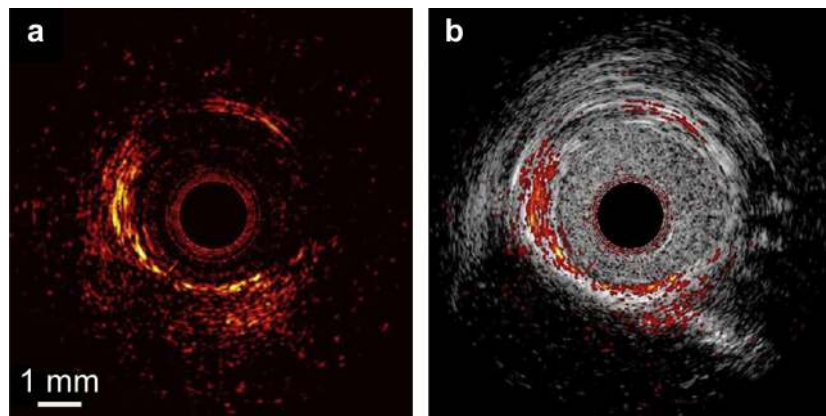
In vivo IVPA/intravascular ultrasound (IVUS) imaging of lipid in an abdominal rabbit aorta. (a) IVPA image and (b) combined IVPA/IVUS image. The location of lipid deposits in the vessel wall is visualized in the combined IVPA/IVUS image. Adapted from Wang et al. (2012a).
